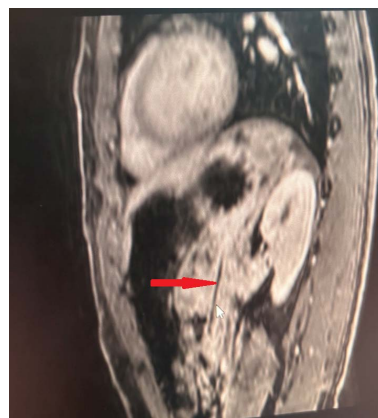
Abdominal MRI, sagittal section. On the projection of the duodenum and retroperitoneal adipose tissue, a straight, linear shadow of toothpick is determined.
